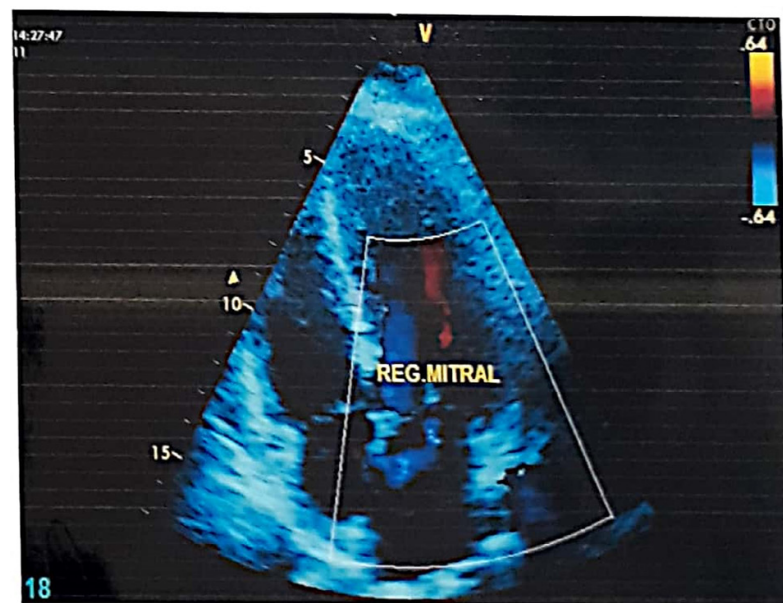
Stress echocardiography showing thickened mitral valve with mild regurgitation and diffuse hypokinesia with mild systolic dysfunction.
